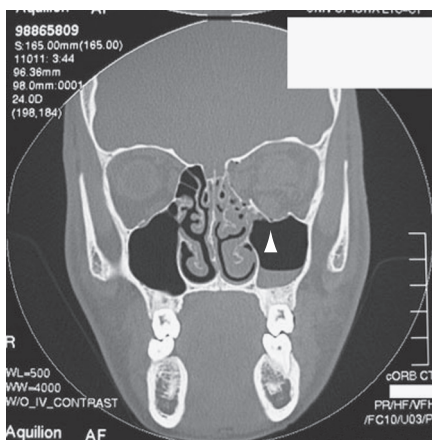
Facial computed tomography (CT) scan showing left inferior orbital fracture with blood in maxillary sinus. (Courtesy University of Iowa Department of Ophthalmology, http://webeye.ophth.uiowa.edu/eyeforum/Images/floorfx_08232004.jpg.)
